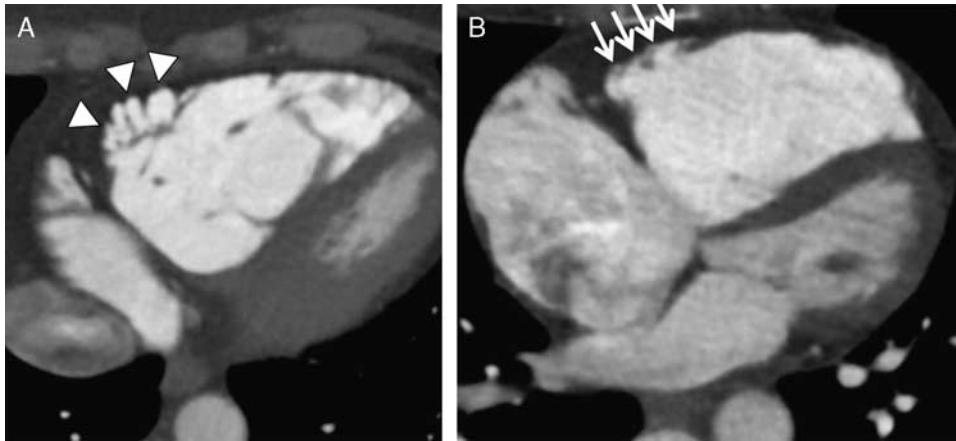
CT findings in ARVC/D. A, Axial image from a cardiac CT obtained in a 40-year-old woman with ARVC/D. The RV is dilated, and there are multiple focal areas of outward bulging along the RV free wall, which can be described as microaneurysms (arrowheads). B, More superiorly, the RV is clearly markedly dilated with subtle irregularity of the subtricuspid region of the RV free wall, likely from fat infiltration (arrows).
